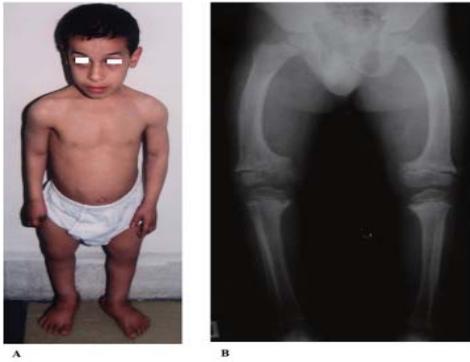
Case 14 with SEMDJL at 8 years of age. Frontal view showing clinical features (A). X-ray of pelvis and long bones of lower limbs showing shallow acetabulum, oblique bowed femora, widening and fraying of metaphyses and indentations of epiphyses (B).
